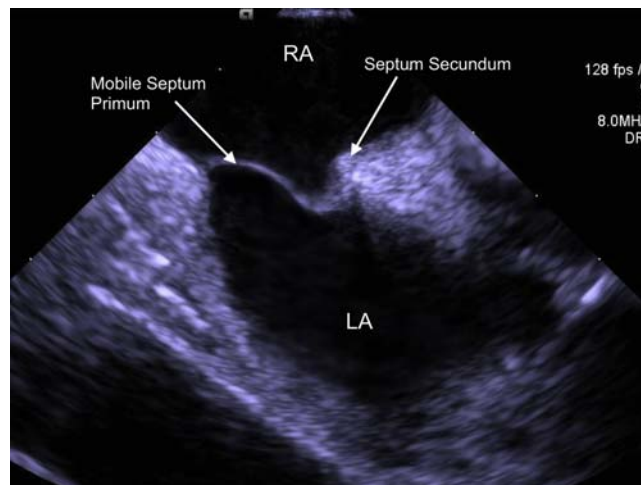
Aneurysmal mobile septum primum and thicker more stable septum secundum seen with intracardiac echocardiography imaging.
